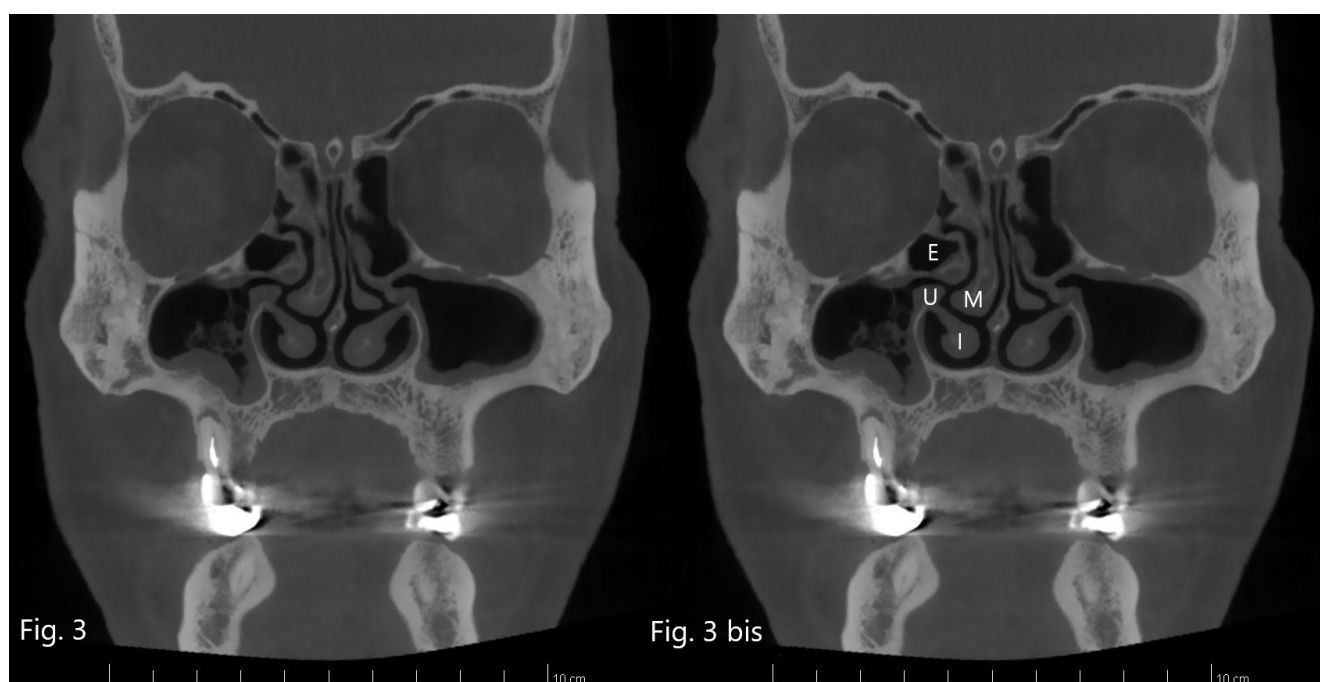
and 3bis. Cone beam CT (coronal slices) depicting the anatomy of the uncinate process.
